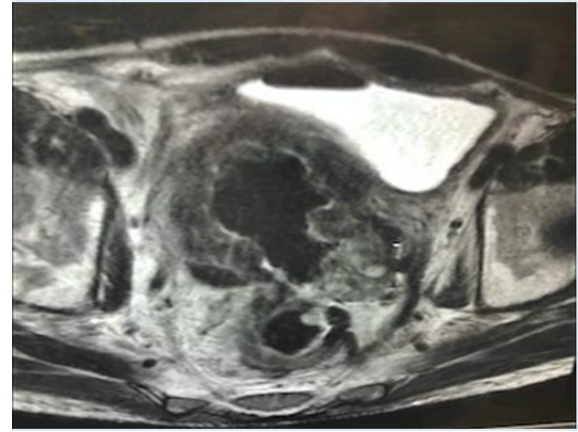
Abdominopelvic CT scan after chemotherapy showing partial radiological improvement.
